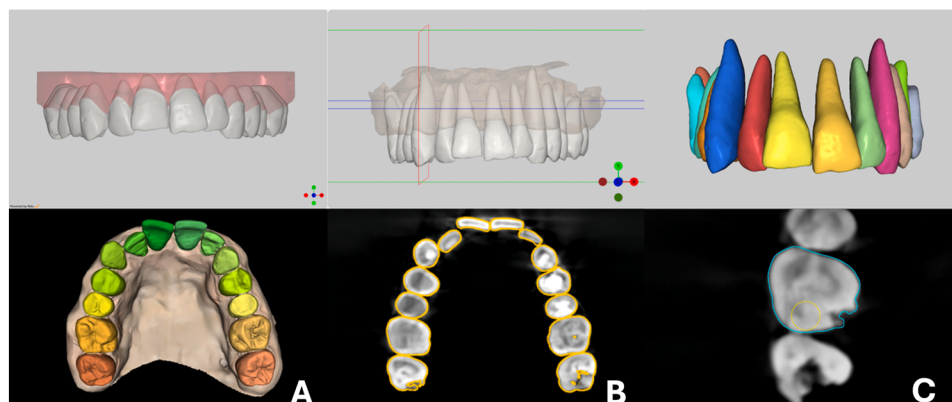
Segmentation techniques: A, IOS scan (*top*) and subsequent segmentation (*bottom*) using the Relu platform (Relu BV); B, CBCT and IOS segmentation fusion (*top*) with corresponding axial view from the CBCT scan (*bottom*); C, Fused models uploaded to Blue Sky Plan (Blue Sky Bio) (*top*) followed by contour modification (*bottom*) using the move outlines option (*yellow*) to obtain the fused-adjusted models.
